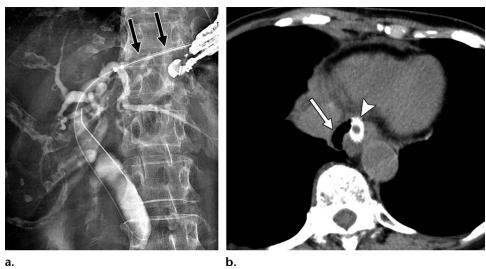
Pneumomediastinum in a 74-year-old man in whom HJS was performed after total gastrectomy for gastric cancer. (a) Fluoroscopic image shows the puncture of the intrahepatic bile duct under endoscopic US guidance and delivery and placement of a metallic stent (arrows). (b) Axial nonenhanced CT image obtained on the day after HJS shows a small amount of asymptomatic gas (arrow) around the esophagus in the mediastinum. The metallic stent can be seen in the esophagus (arrowhead).
